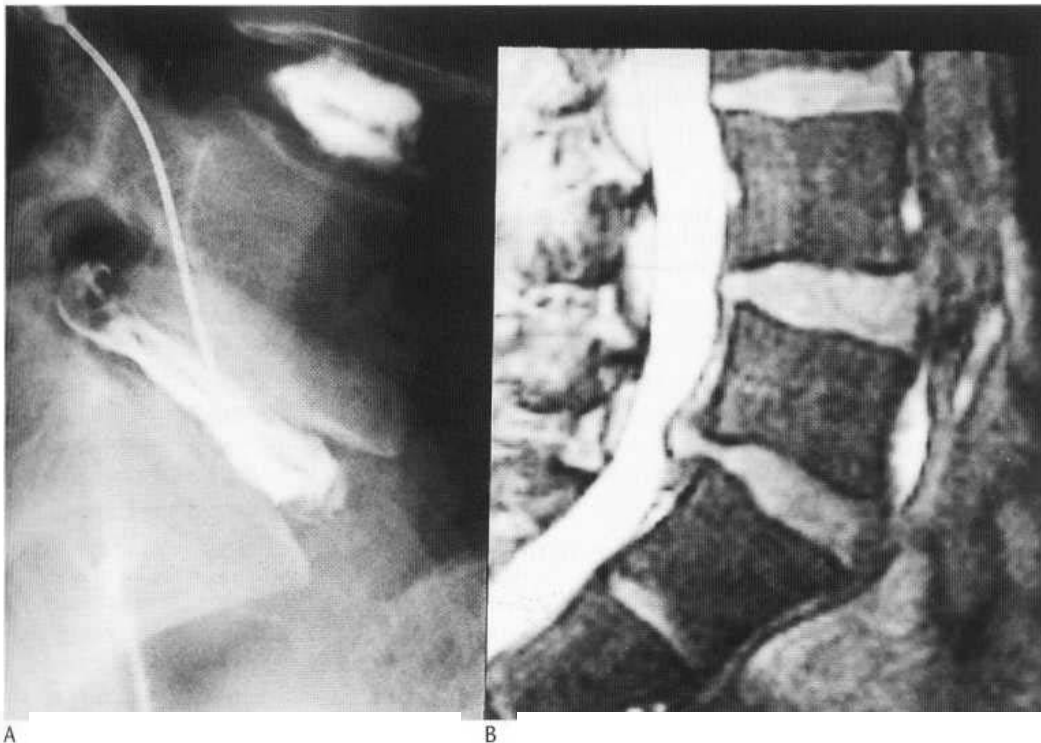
(A,B) MRI and discography demonstrate a dorsal distal protrusion with narrowing of the canal at that level.
